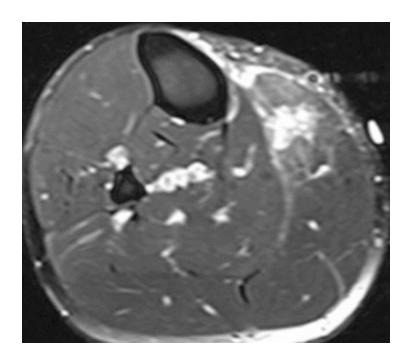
Axial fat-suppressed T2-weighted MRI of right mid-calf shows severe muscle contusion of the gastrocnemius lateralis associated with rupture of the deep and superficial aponeurosis
